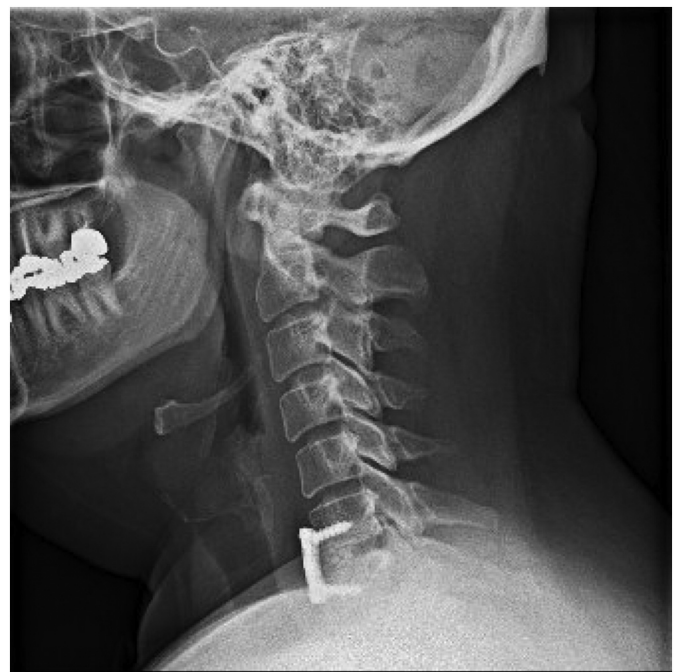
Five-month Post-operative lateral cervical spine X-ray demonstrating anterior fusion of C6–C7 in standard alignment with no evidence of hardware complication, as well as partial bone graft incorporation at the C6–C7 disc space.
